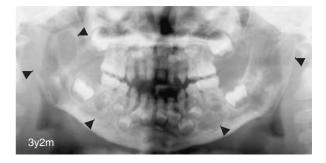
Panoramic radiograph at 3 years and 2 months: multiple jaw lesions including the tooth-germ of permanent lower premolars (arrowhead).
